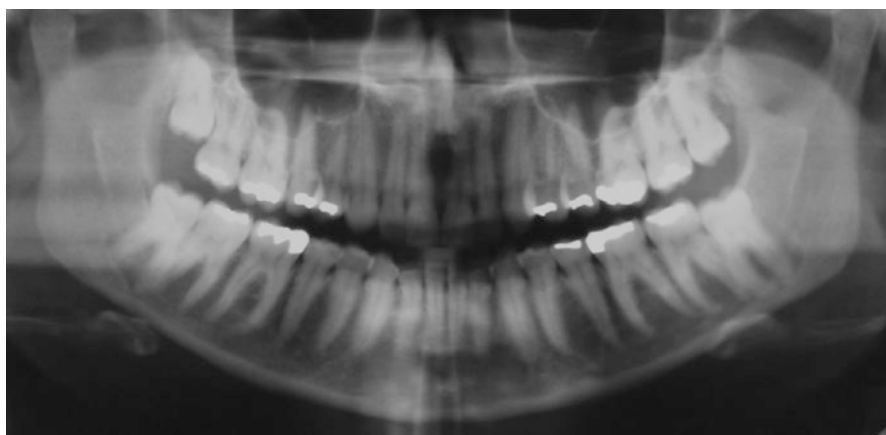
Panoramic radiograph reveals impacted tooth #1, impacted #17 with hypercementosis, Pell and Gregory type 2B and impacted #32, also with hypercementosis and Pell and Gregory type 1A
